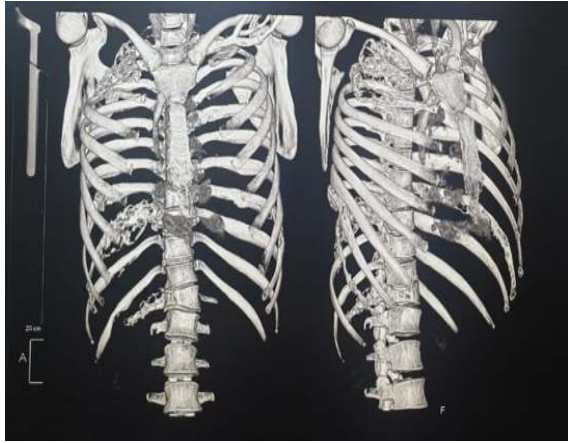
CT Thorax:multiple sclerotic lytic vertebrae(D8,D9,D10 and D12) and lytic cystic ribs(1,2,8,9,12 on right side and 8th rib on left side)
